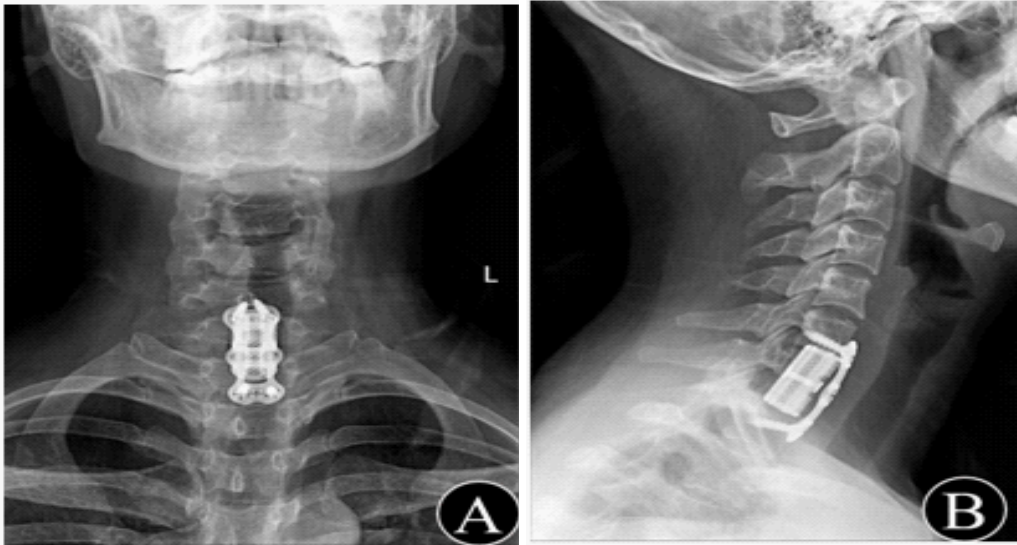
(A,B) The anterolateral X-ray of the cervical spine was re-examined 3 days after surgery, and the internal fixation position was good, and the intervertebral space was highly satisfactory.
